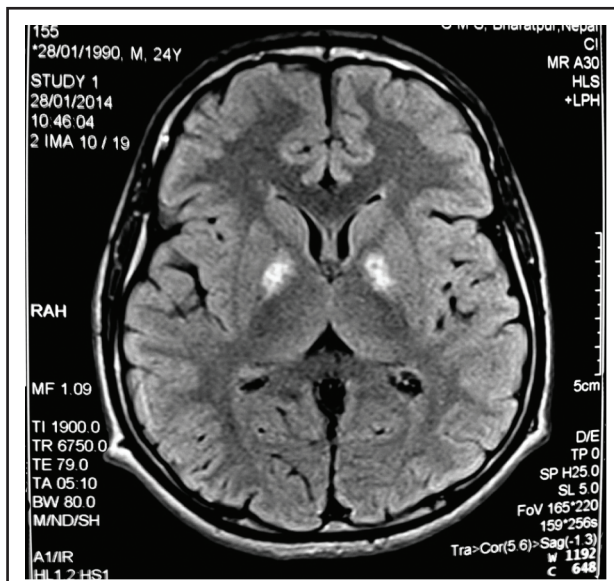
Axial section Inversion recovery sequence (FLAIR)
